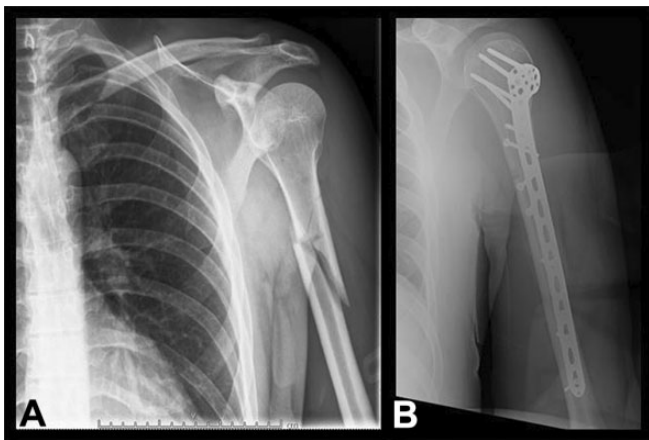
Patient 1: (A) injury radiograph and (B) postoperative radiograph after open reduction and internal fixation.
